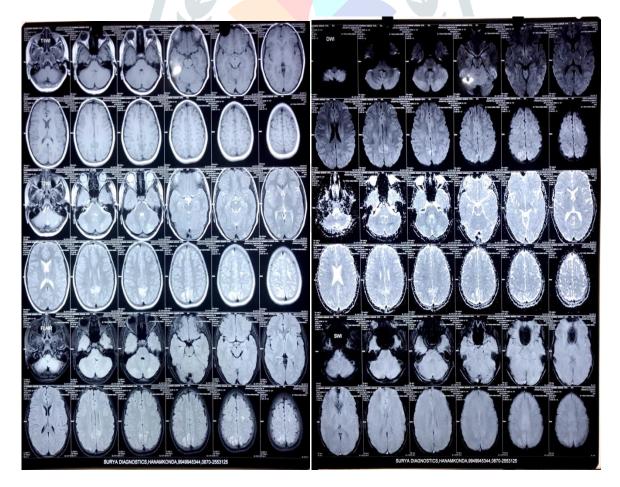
MRI of brain demonstrating Hyperintensity lesions seen in posterior part of high parietal region along with the surrounding edema suggestive of PRES.
